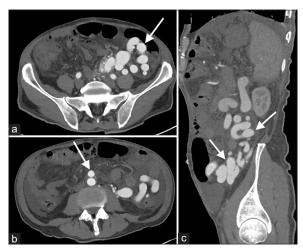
A 72-year-old male with a colonic arteriovenous malformation (AVM) who presented with ascites. Contrastenhanced CT shows (a) a large AVM (arrow) surrounding the sigmoid colon, (b) the inferior mesenteric artery (arrow) significantly dilated to near the same size of the adjacent aorta, and (c) a large, tortuous sigmoid colonic vein filling most of the left hemiabdomen (arrows) eventually draining into the main portal
